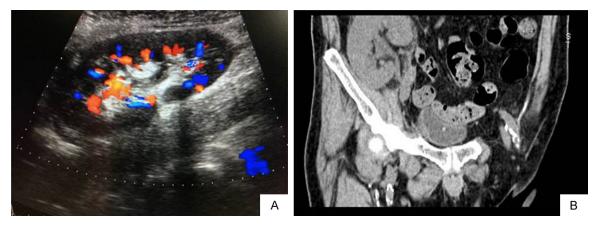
Allograft in recipient. A. One-week post-transplant Color Doppler ultrasound suggests a fine blood supply, though accompanied with strong echo in collecting system. B. Five weeks post-surgery CT on the recipient demonstrates a morphological well-being and stone-free kidney.
